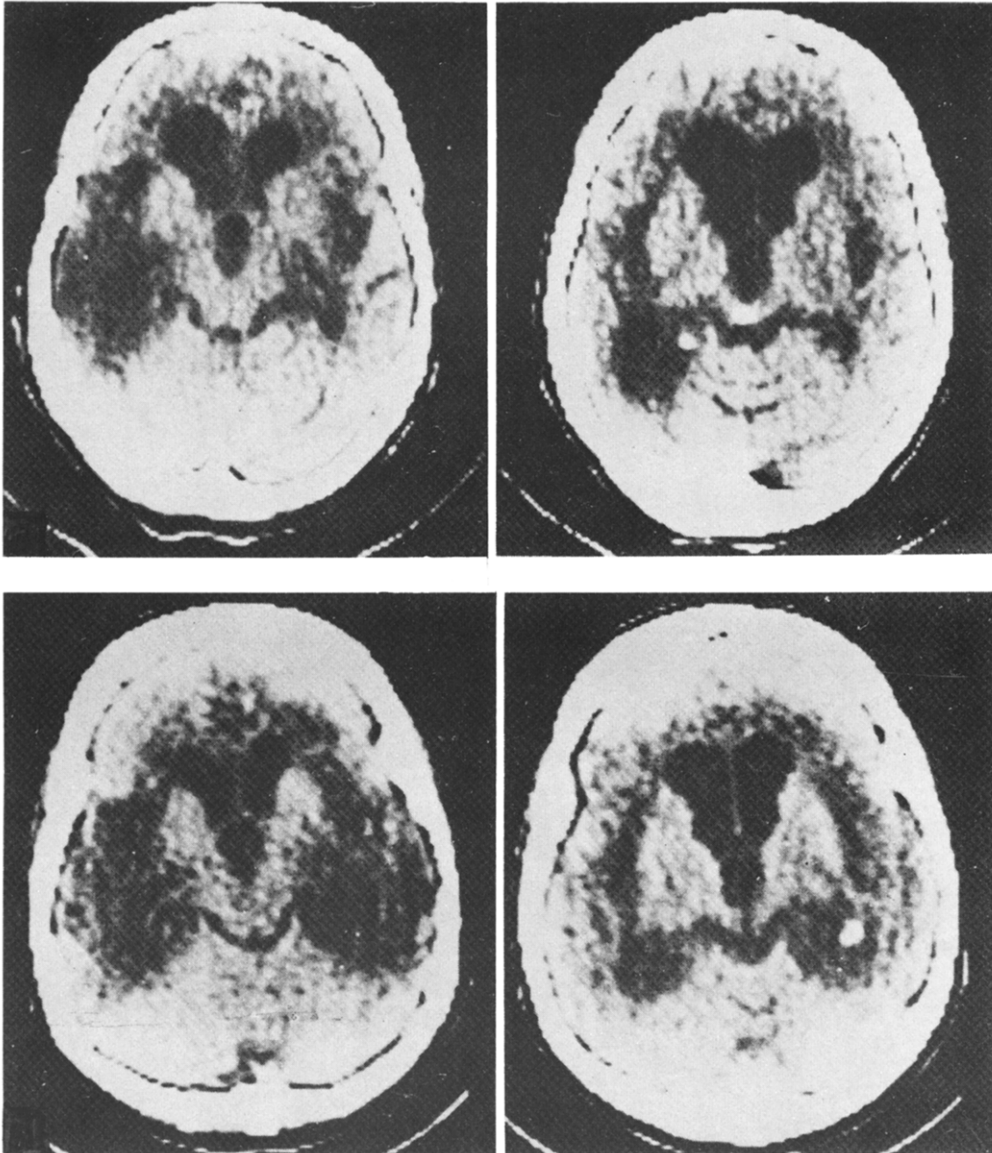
CT-scans of two of the four patients from Warrington and Shallice (1984), demonstrating predominantly bitemporal damage. The upper pictures are from one patient, and the lower from another. (From Warrington and Shallice (1984), reproduced with permission.)
